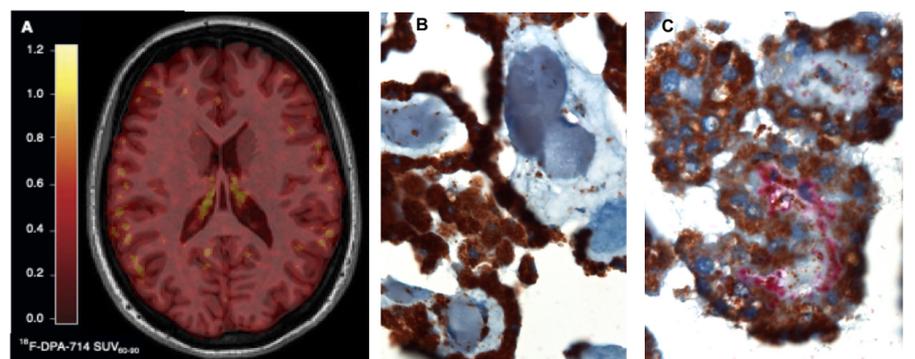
SUV₆₀₋₉₀ map of the case (A); post mortem CP sections from a HC (B) and an MS (C) showing infiltration of TSPO+/CD163+ macrophages in the CP stroma of MS.
